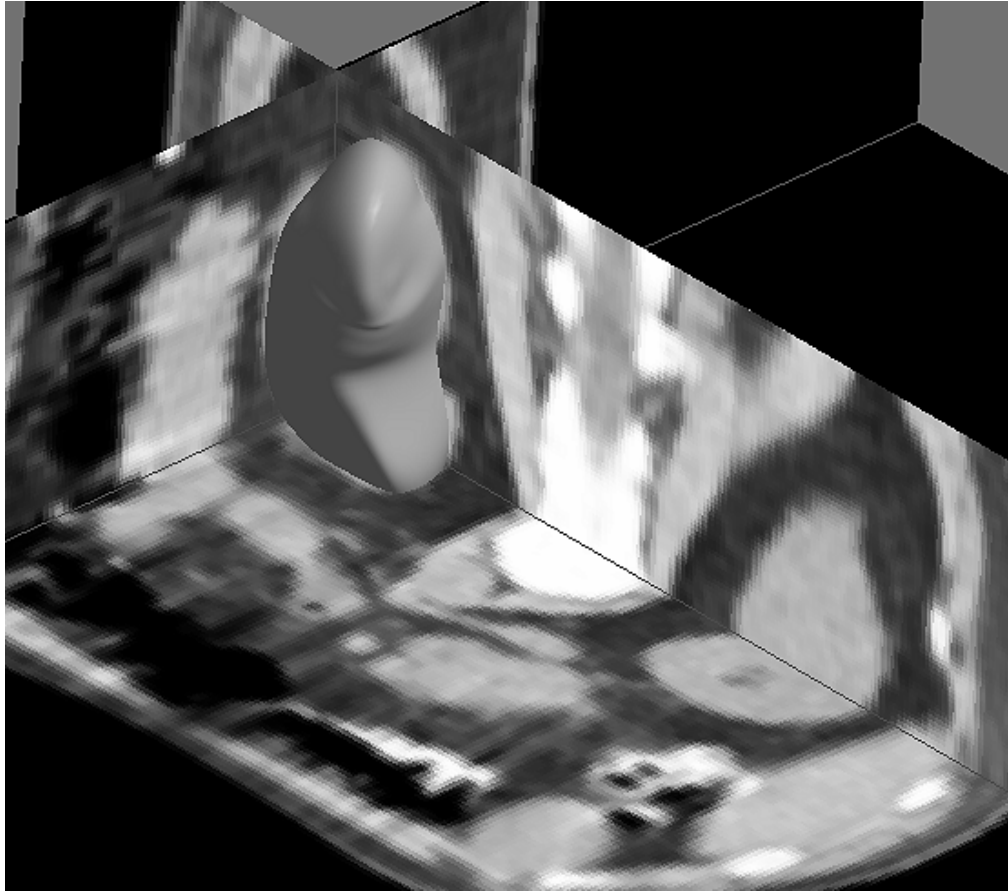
M-rep fit to a kidney in a CT image shown in axial planes.
